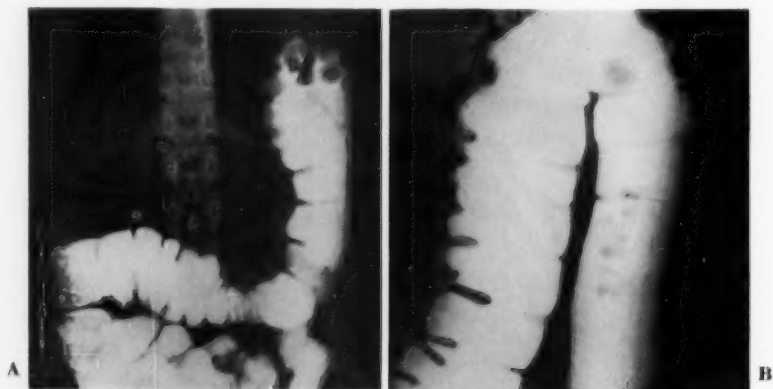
Case 4. *A*, localized involvement of the splenic flexure by pneumatosis. *B*, close-up of splenic flexure showing characteristic roentgen findings in the barium-filled bowel.
